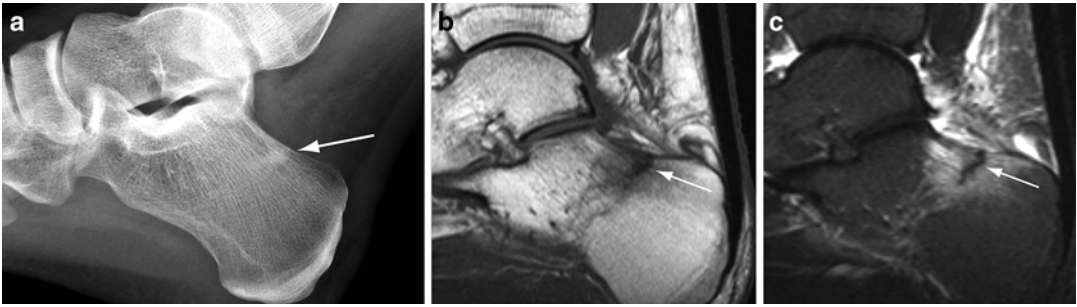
Stress fracture in cancellous bone. (a) Lateral radiograph of the calcaneus demonstrates a linear area of sclerosis perpendicular to the trabeculation in the superior
